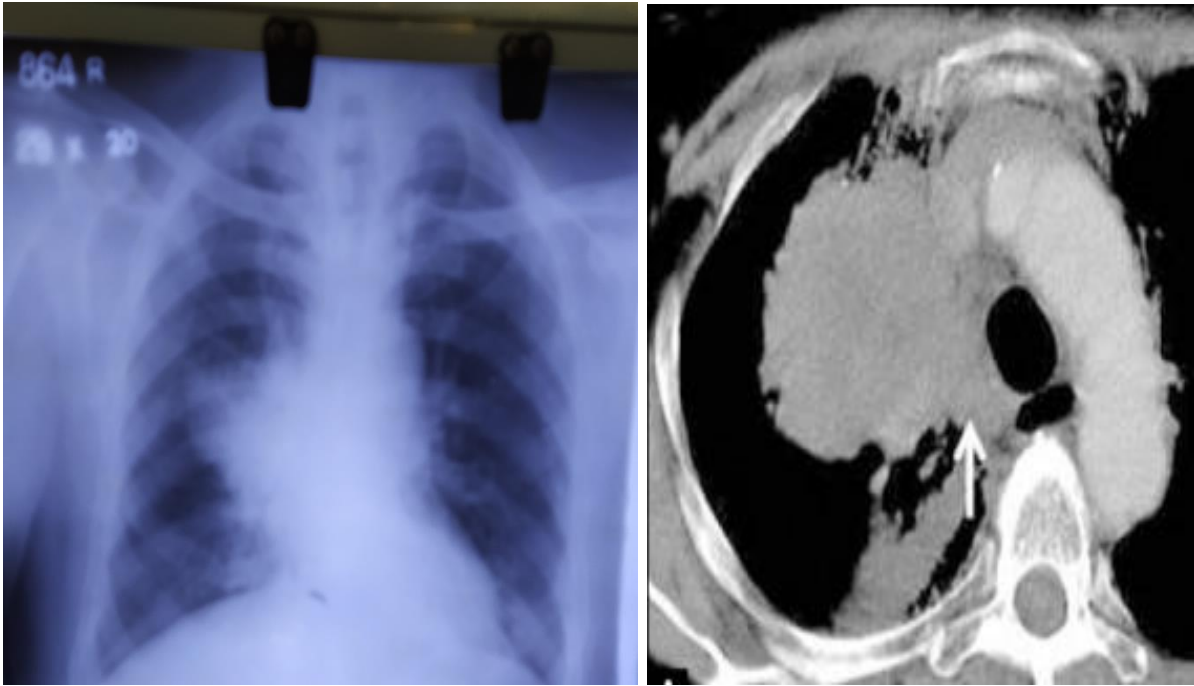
a) Chest X-ray PA view of the patient showing right hilar enlargement, b) CT chest of the same patient showing centrally located mass with irregular margins and mediastinal invasion
